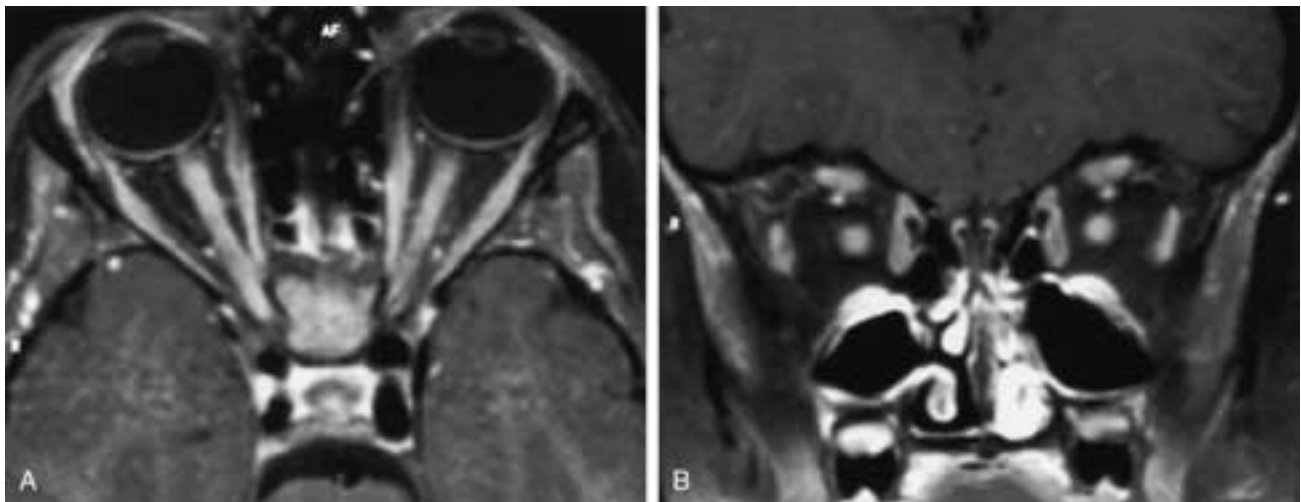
Multiple sclerosis. Bilateral optic neuritis. A and B, Axial and coronal T1-weighted images with fat suppression after gadolinium injection show symmetric enhancement of the intraorbital optic nerves.
